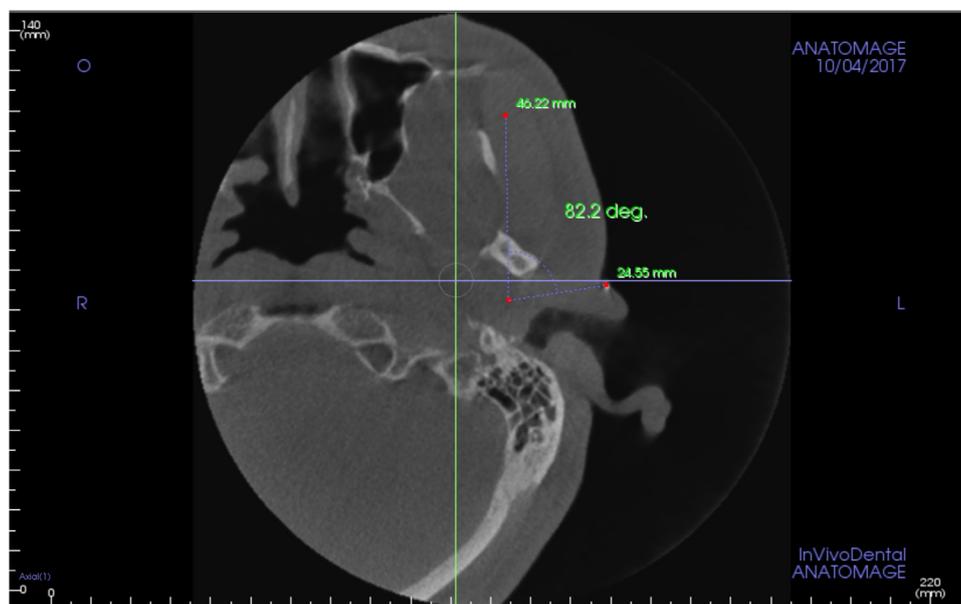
Axial plane of cone-beam computed tomogram showing the distance from the insertion point on the skin to the ideal depth of injection in the upper joint space. The horizontal angle coincided with the perpendicular line drawn on the skin.
